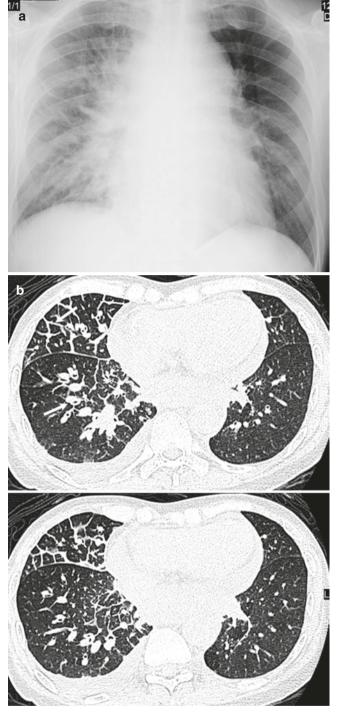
A 57-year-old man with HIV-related Kaposi's sarcoma. (a) Frontal chest radiograph and (b) axial CT image shows septal thickening and peribronchial thickening in right lung (arrows)
